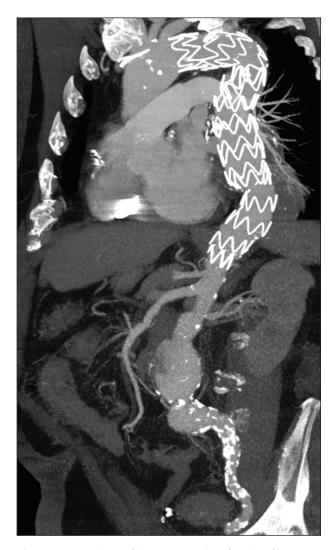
CT angiographic reconstruction showing the Zenith Alpha Thoracic device in a 72-year-old patient with aneurysmal disease of the thoracic, thoracoabdominal, and abdominal segments. Note the alignment of the stent graft with the tortuous aortic segments, as well as the presence of heavily calcified iliac arteries.
